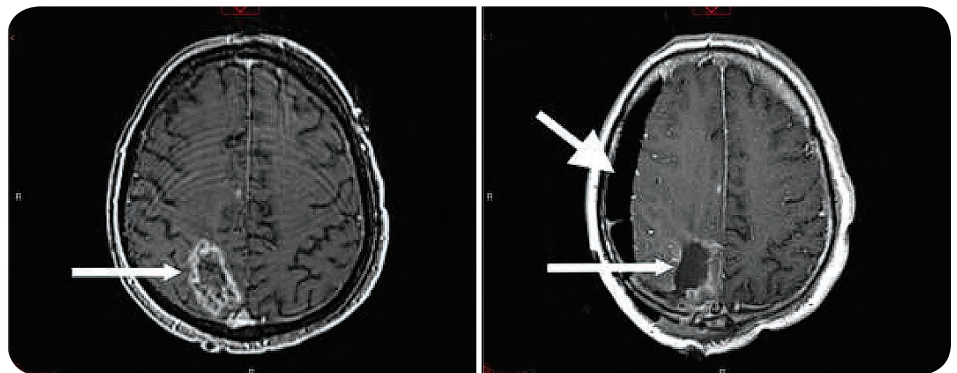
In the left panel, the arrow identifies the tumor on a PRE-operative, T1 weighted, contrast enhanced axial MR image. In the right panel, the similar arrow identifies the resection cavity on an INTRA-operative, T1 weighted, contrast enhanced axial MR image. Also in the right panel, the larger arrow indicates the presence of intracranial air in the subdural space. As can be seen by comparing the left and right panels, the brain has shifted due to the craniotomy and the resection of tumor.
